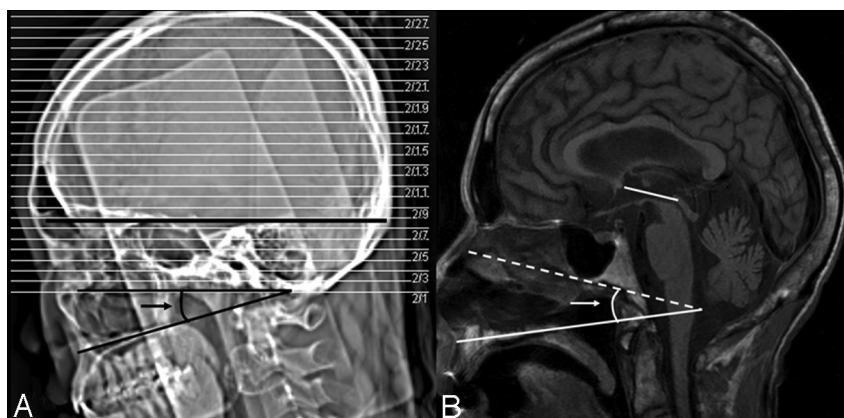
A, Measurement of the angle between the TS-OP line and the hard palate in the lateral scout view of the brain CT (black arrow). B, Measurement of the angle formed by the ACPC line and the hard palate (white arrow) to calculate the angle difference between the TS-OP line and the ACPC line in the midsagittal T1-weighted brain MR image.
